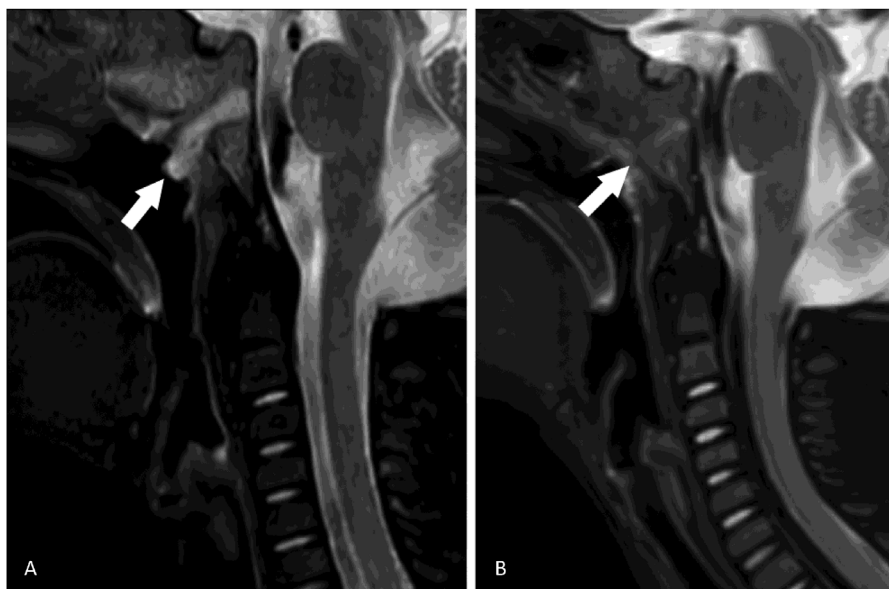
A) Sagittal fat-suppressed T2-weighted MR image of the craniocervical junction reveals inflammatory tissue widening the spheno-occipital synchondrosis (arrow) consistent with osteomyelitis. B) Similar imaging, following therapy, demonstrates resolution of inflammation (arrow).
